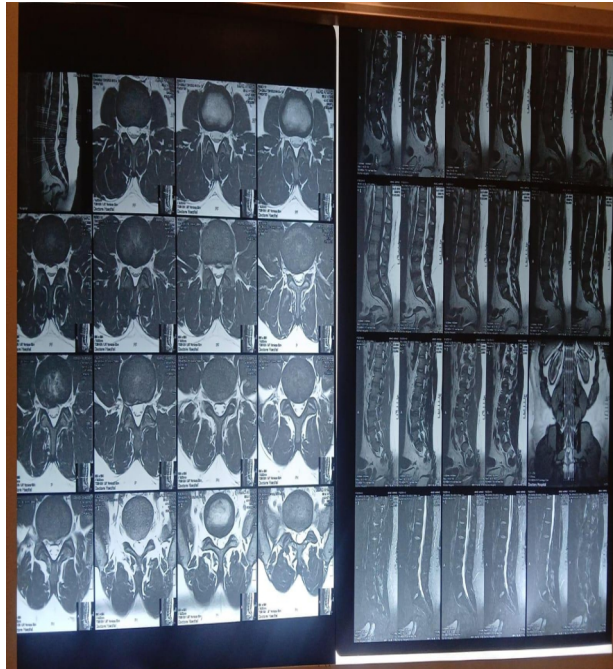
Multiplanar MRI of the lumbar spine showing bilateral L3 pars interarticularis defects. (A-D) Axial T2-weighted MRI slices demonstrating symmetric bilateral defects with spinal canal involvement. (E-H) Sagittal T2-weighted reconstructions showing Grade I anterolisthesis and disc signal changes.
